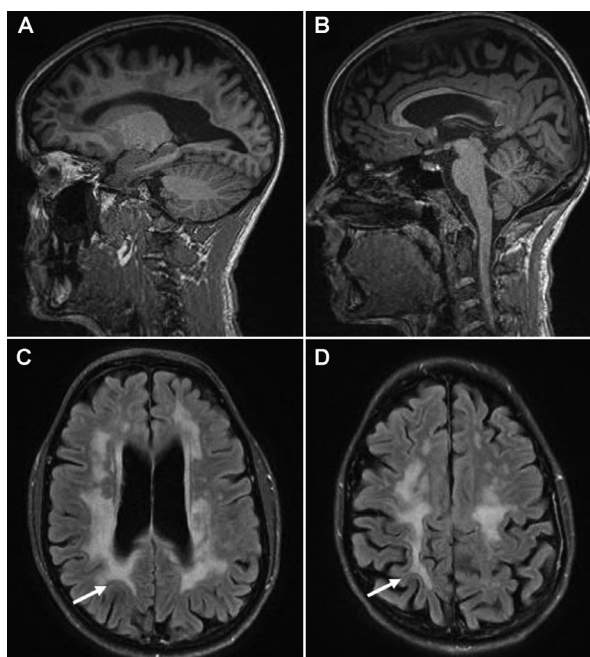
Case 4: MRI of the brain. A. Sagittal T1 MRI shows predominantly parietal and frontal lobe cortical atrophy with ex vacuo ventriculomegaly, and B. thinning of the corpus callosum. C. and D. Axial T2 FLAIR MRI shows hyperintensities in the periventricular and subcortical regions, with sparing of the cortical U-fibres (arrows)
